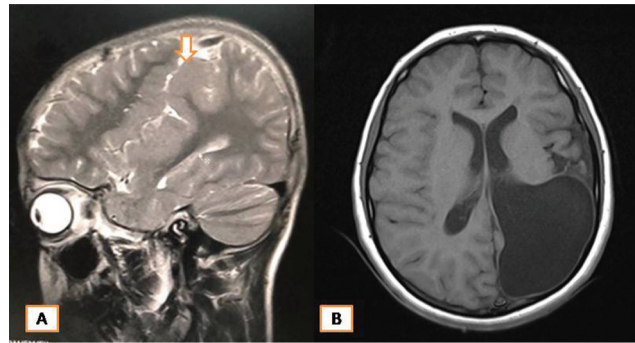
Magnetic resonance imaging (MRI) brain sagittal T2-weighted imaging: diffuse cortical thickening with blurring of sulci and gyri formation suggestive of pachygyria in left Sylvian fissure. (A) MRI brain axial T1-weighted imaging: severe encephalomalacia noted in the left parieto-occipital region with a thin-walled cerebrospinal fluid signal intensity lesion in left parieto-occipital lobe with communication with the left lateral ventricle.
